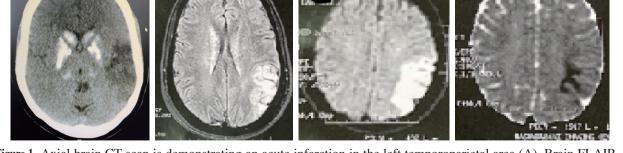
Axial brain CT scan is demonstrating an acute infarction in the left temporoparietal area (A). Brain FLAIR, DWI, and ADC imagings are showing hyperintensity (B), and restricted diffusion (C, D) respectively.
